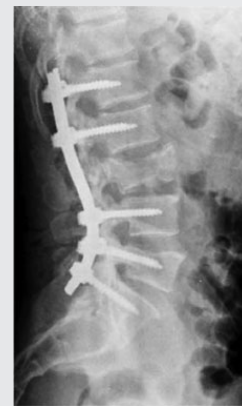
Standing post-operative radiograph following posterior approach.
